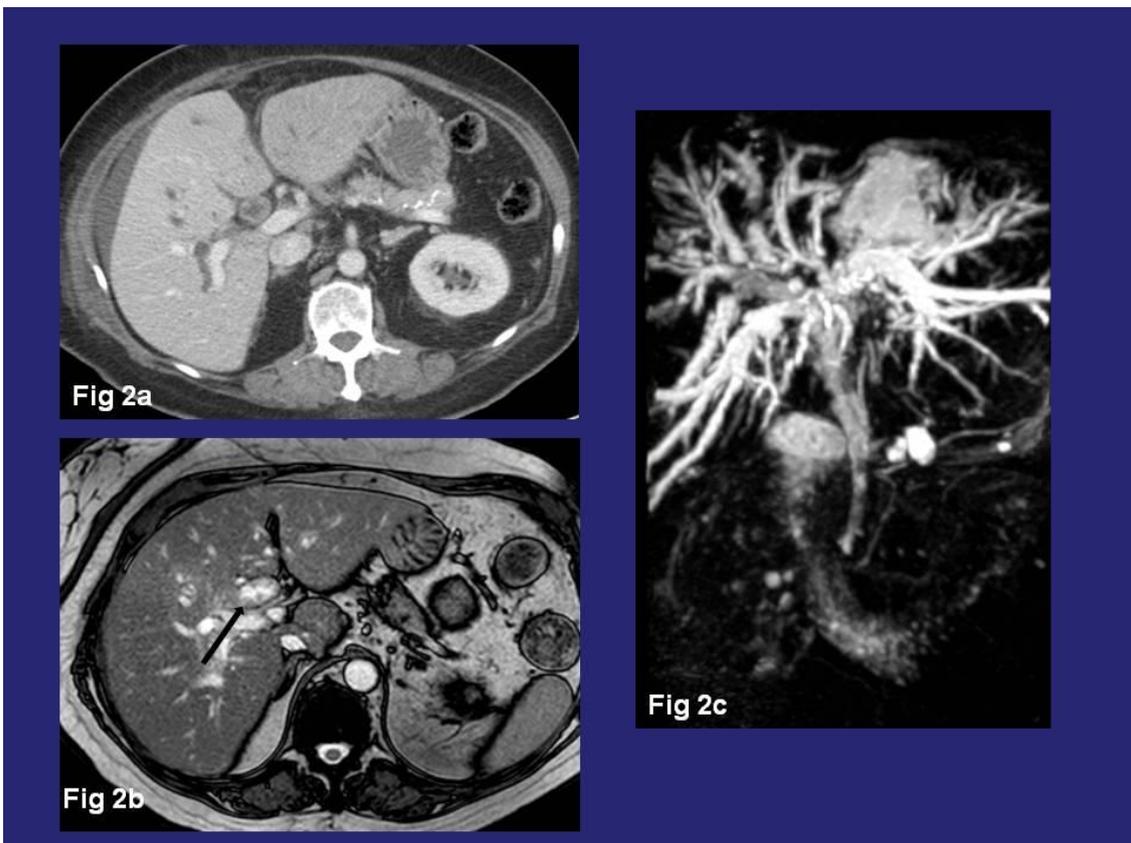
Patient of figure 1. Contrast-enhanced CT (figure 2a) shows dilated common bile duct, with presence of multiple polyps on their wall; and dilated peripheral bile ducts. T2-weighted MR image (figure 2b) shows multiple polypoid tumors (black arrow). MR cholangiopancreatography (figure 2c) shows markedly dilated intrahepatic ducts.
